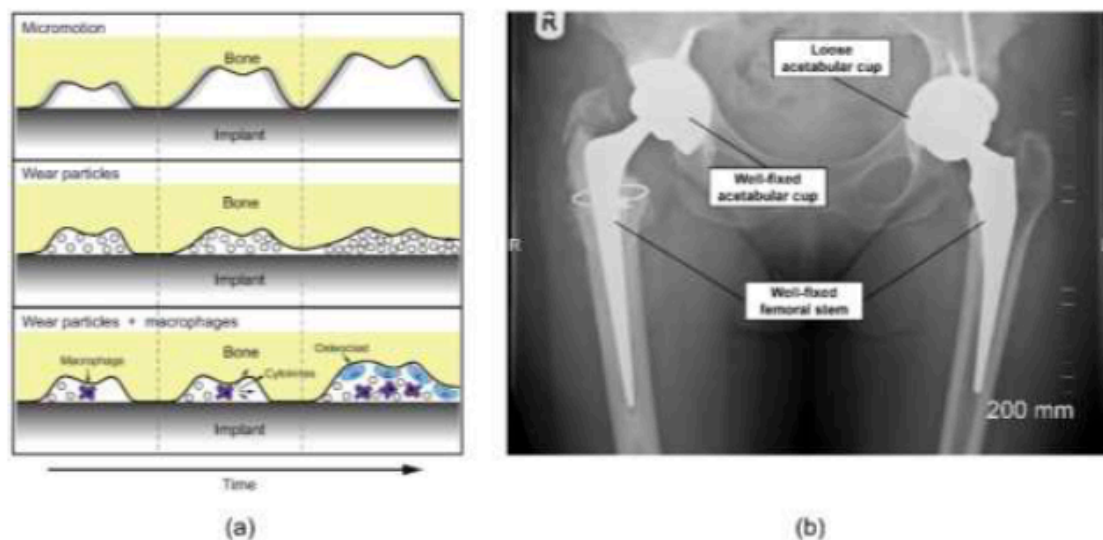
(a) Aseptic loosening pathways: (top) progressive micromotion of the implant; (middle) wear products interfering with direct bone-implant contact; (bottom) wear particles activating macrophages, leading to bone resorption [39]. (b) Antero-posterior (AP) plain radiograph showing a loose acetabular cup that was revised.
